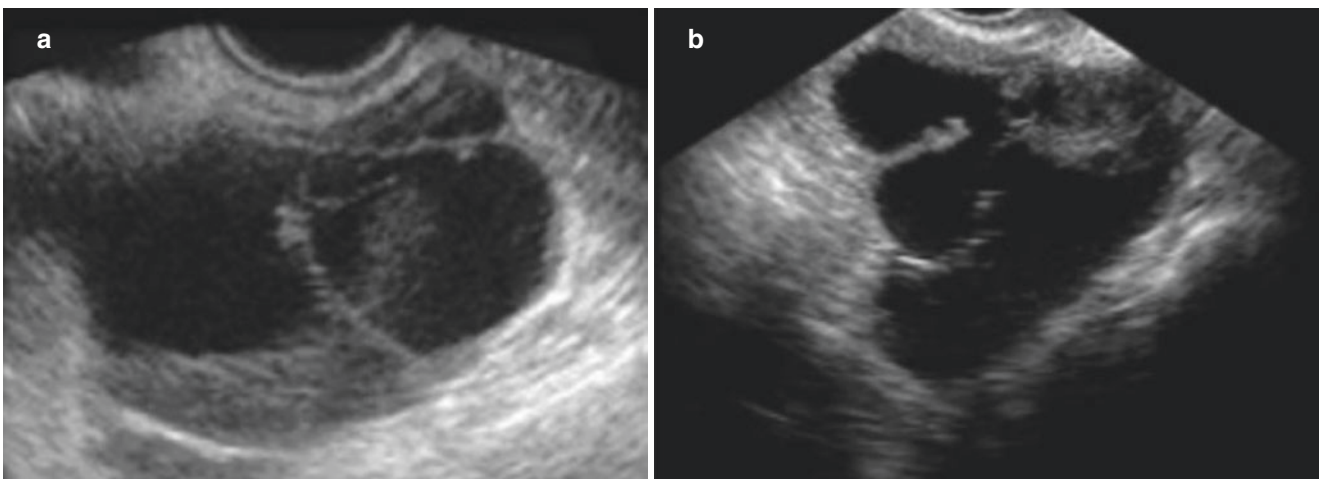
Pelvic encapsulated effusion. (a–d) Sonogram shows an irregular fluid lesion in the pelvis of a patient after hysterectomy. Septum is visible inside, and some patients may have lower abdominal pain
